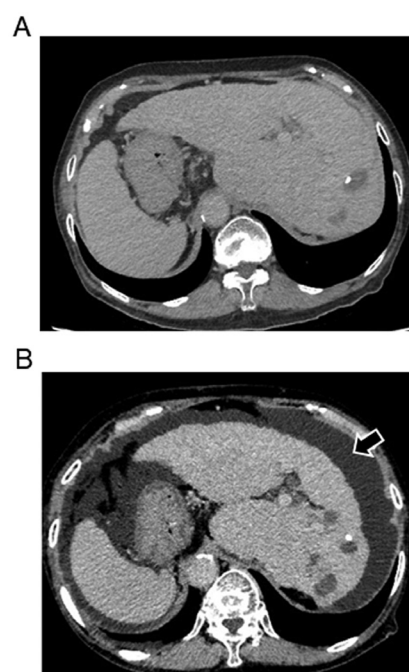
Representative CT images of a patient with visceral inversion administered with RAM. (A) CT image before administration of RAM. No ascites are seen. (B) CT image 27 days after administration of RAM. Severe ascites are seen (arrow). CT, computed tomography; RAM, ramucirumab.
